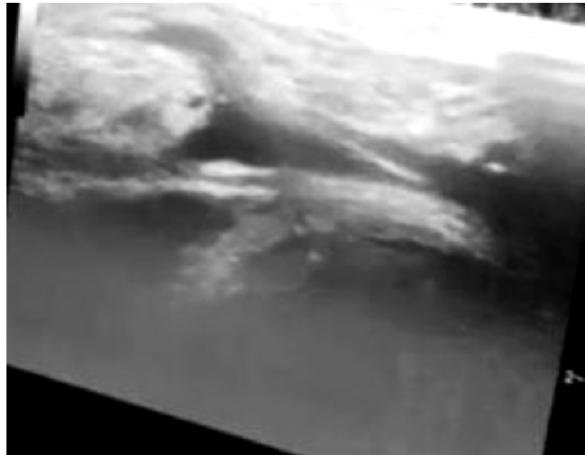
After successful single wall puncture of the vein, introduction of the needle into vein lumen is done under ultrasound guidance.
